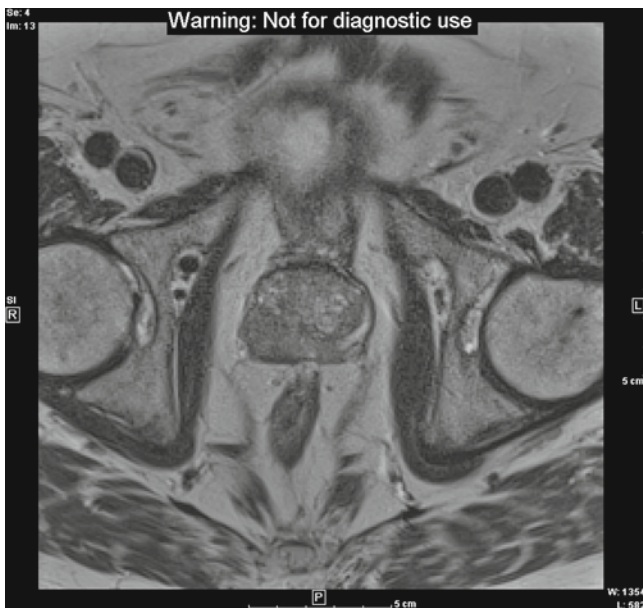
Axial T2 MRI of the prostate demonstrate focal disease in the right peripheral zone of the prostate with convincing tumor passing through the capsule of the gland consistent with T3a disease
